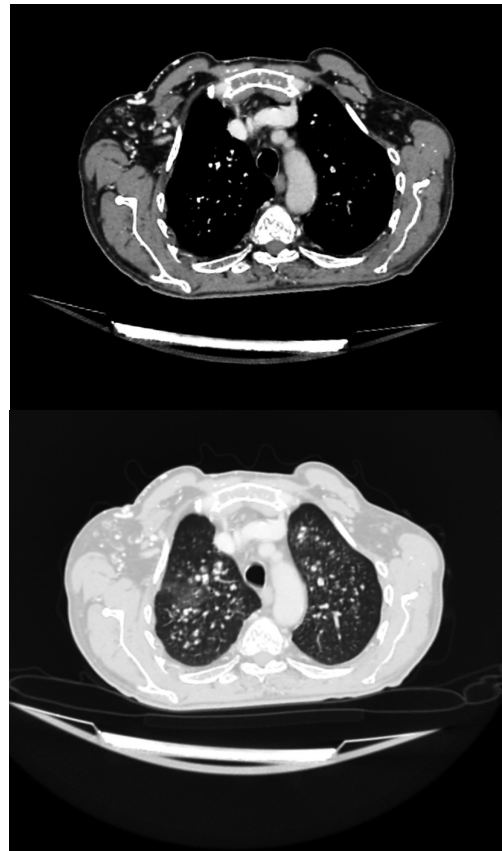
Axial contrast enhanced computed tomography with (a) mediastinal and (b) parankimal windows reveal ground-glass opacities associated with poorly defined centrilobular nodules and numerous calcific nodules
